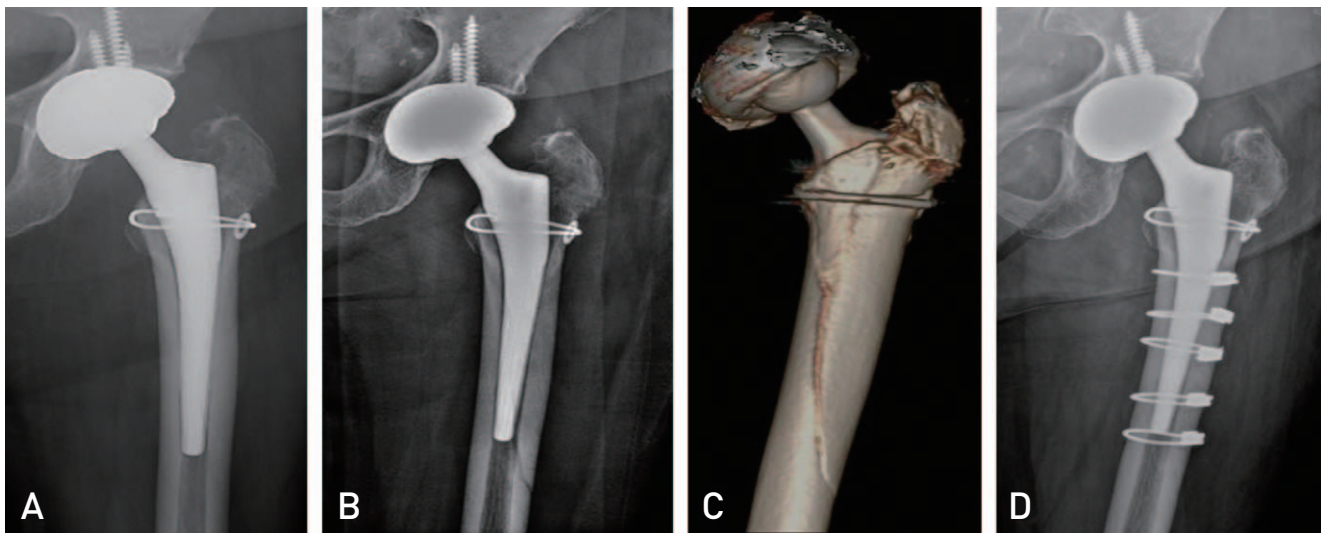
A 75-year-old female who underwent total hip arthroplasty using a Corail® stem. (A) Immediate postoperative radiograph. (B) Two-week postoperative radiograph. (C) Three-dimensional computed tomography reconstruction image. (D) One-year post-revisional radiograph after multiple cerclage wiring.
